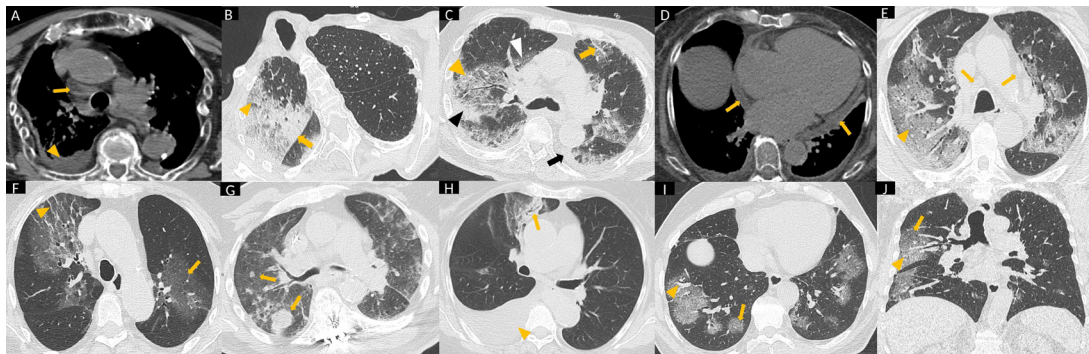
Chest CT images at time of admission showing COVID-19 presentations in 10 patients. (A) Case 1: bilateral PE (arrowhead) and right paratracheal lymphadenopathies (arrow) are observed. (B) Case 2: unilateral lung involvement. CPp (arrowhead) and CONS (arrow) are shown in the RUL. (C) Case 3: bilateral and patchy GGO (white arrowhead) with CONS (black arrowhead) and CPp (yellow arrowhead) are identified in upper lobes. Minimal bilateral PE (black arrow) and vascular ingurgitation (yellow arrow) are also observed. (D) Case 4: CT showing mild pericardial effusion (arrow) in a patient with cardiomegaly. (E) Case 5: predominant CPp (arrowhead) in upper lobes with mediastinal lymph node enlargement (arrows) is observed. (F) Case 6: axial CT images showed bilateral GGO (arrows) in upperlobes with bronchiectasis and peripheral fibrotic tracts (arrowhead). (G) Case 7: peripheral GGO, predominantly in the LUL, in a patient with lung metastases (arrows). (H) Case 8: GGO with CONS in the RUL. Air bronchogram (arrow) and right PE (arrowhead) are shown. (I) Case 9: predominant-GGO pattern with multilobar involvement and peripheral distribution is observed. Round-shaped opacities (arrow) withvascular ingurgitation (arrowhead) are identified. (J) Case 10: CT coronal reconstruction (lung parenchyma window) showing GGO (arrow) and CPP (arrowhead) in the right lung. CONS, consolidation; CPp, crazy paving pattern; GGO, ground-glass opacities, LUL, left upper lobe; PE, pleural effusion; RUL, right upper lobe.
